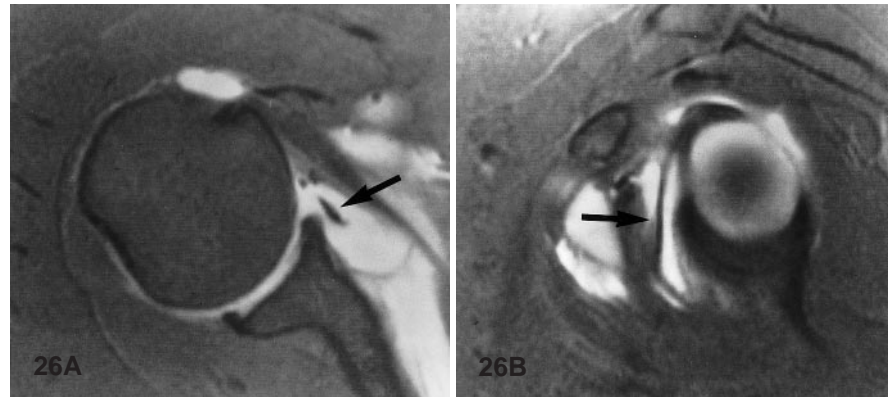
Buford complex. Axial (A) and sagittal oblique (B) fat-suppressed T1-weighted MR images (SE 516/13) after intra-articular gadolinium injection. The middle glenohumeral ligament (*arrow*) is thick, and the anterior labrum (*arrowhead*) is absent. This normal variant should not be mistaken for a Bankart lesion
